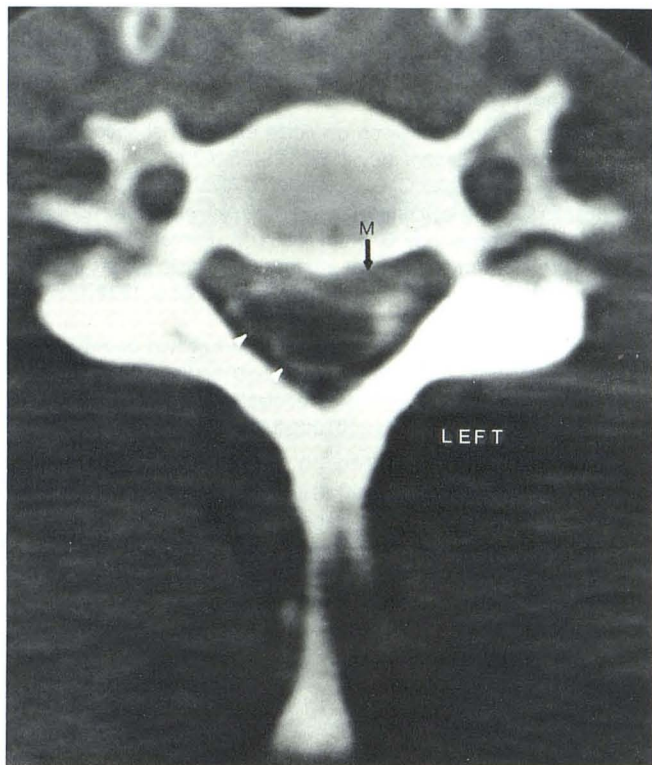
Metrizamide CT scan at C6 level shows thinning of the metrizamide column on the right (*white arrowheads*), epidural soft-tissue mass (M), and asymmetry of the dural sac with cervical cord displacement to the right.
